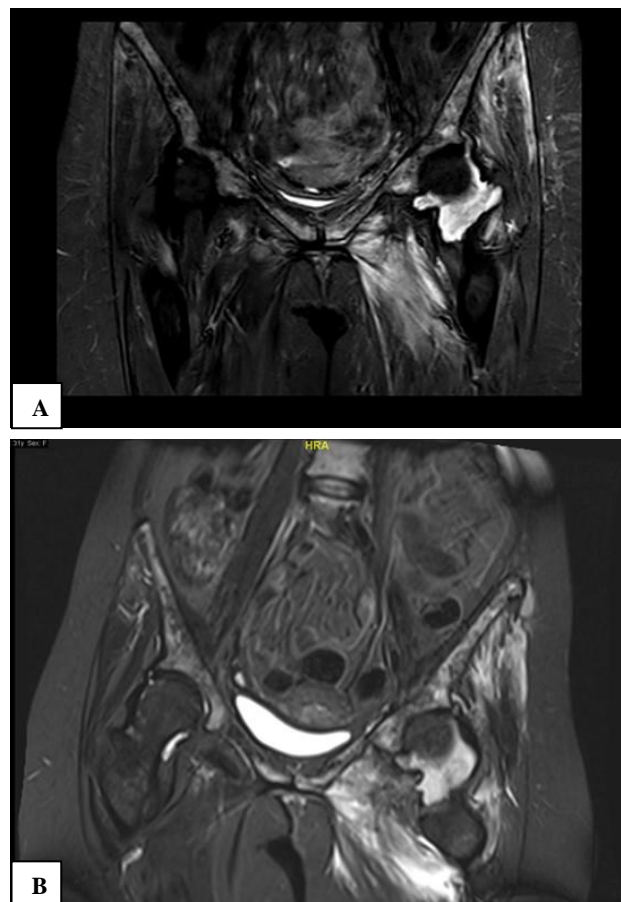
(A and B): MRI.
